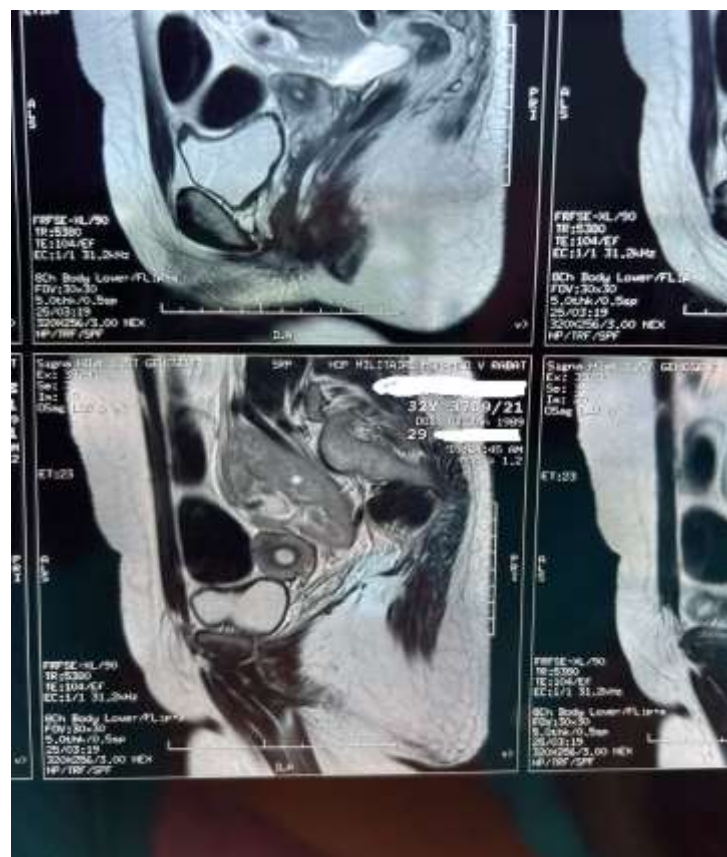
Sagittal MRI slice showing the pelvic kidney.
